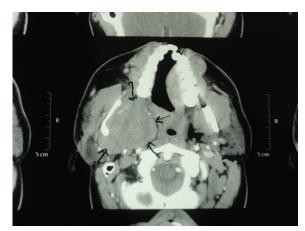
Contrast enhanced axial CT showing a well-defined homogeneous soft tissue mass involving the right parotid gland.
